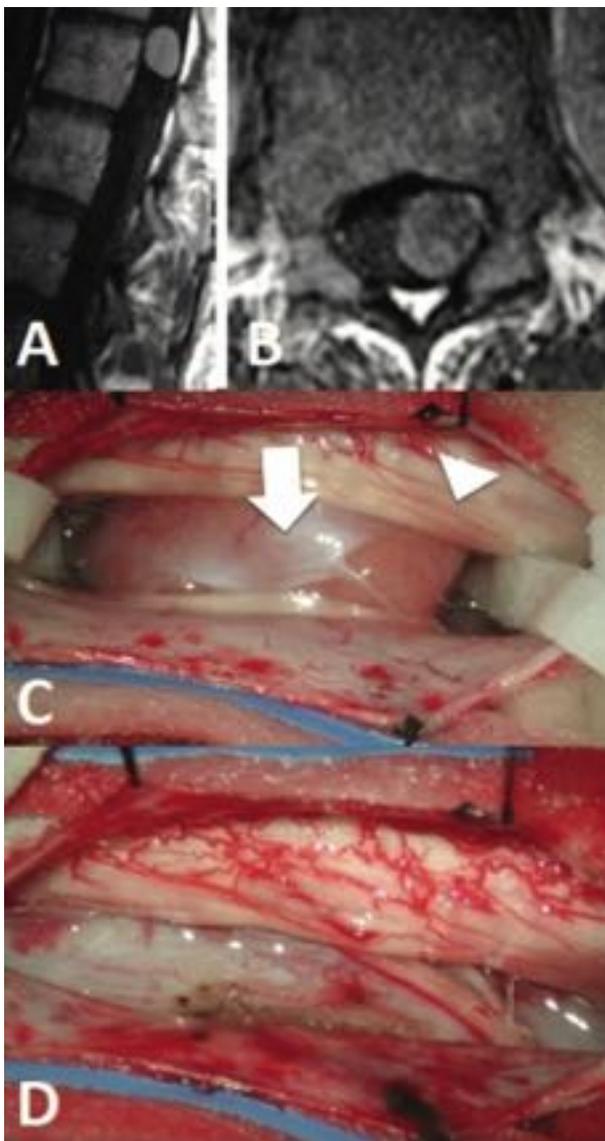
(A) T1 sagittal and (B) T1 axial magnetic resonance imaging scans with contrast demonstrate a ventrolateral spinal meningioma at the level of L1. (C) At initial exposure, the dentate ligament is shown draped over the tumor (*arrow*), and the cauda equina (*arrowhead*) is observed displaced to the lateral aspect of the canal. (D) The tumor is fully resected with preservation of the dura to facilitate dural closure and minimize the chance of cerebrospinal fluid leakage.
